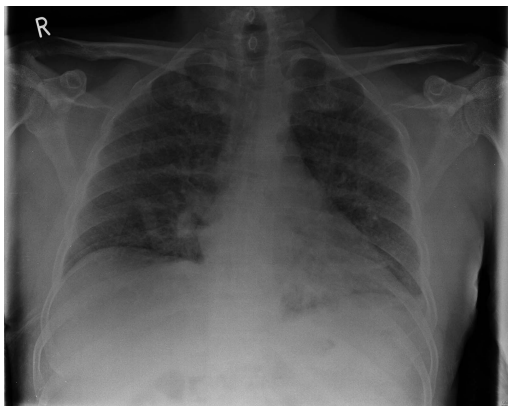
The patient's initial chest radiograph on admission to the hospital: showing bilaterally diffuse increased shadowing consistent with mild pulmonary oedema.
